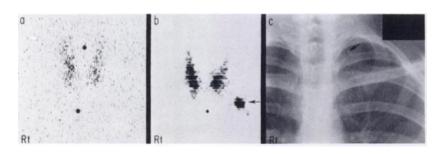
(a) Thyroid scan performed with 200 μ Ci of I-131. (b) Fluorescent thyroid scan performed 1 day before that in (a), showing an area of high iodine content in left supraclavicular region (arrow) (c) Anterior chest roentgenogram showing iodide in supraclavicular lymph node (arrow) from previous lymphangiogram.
